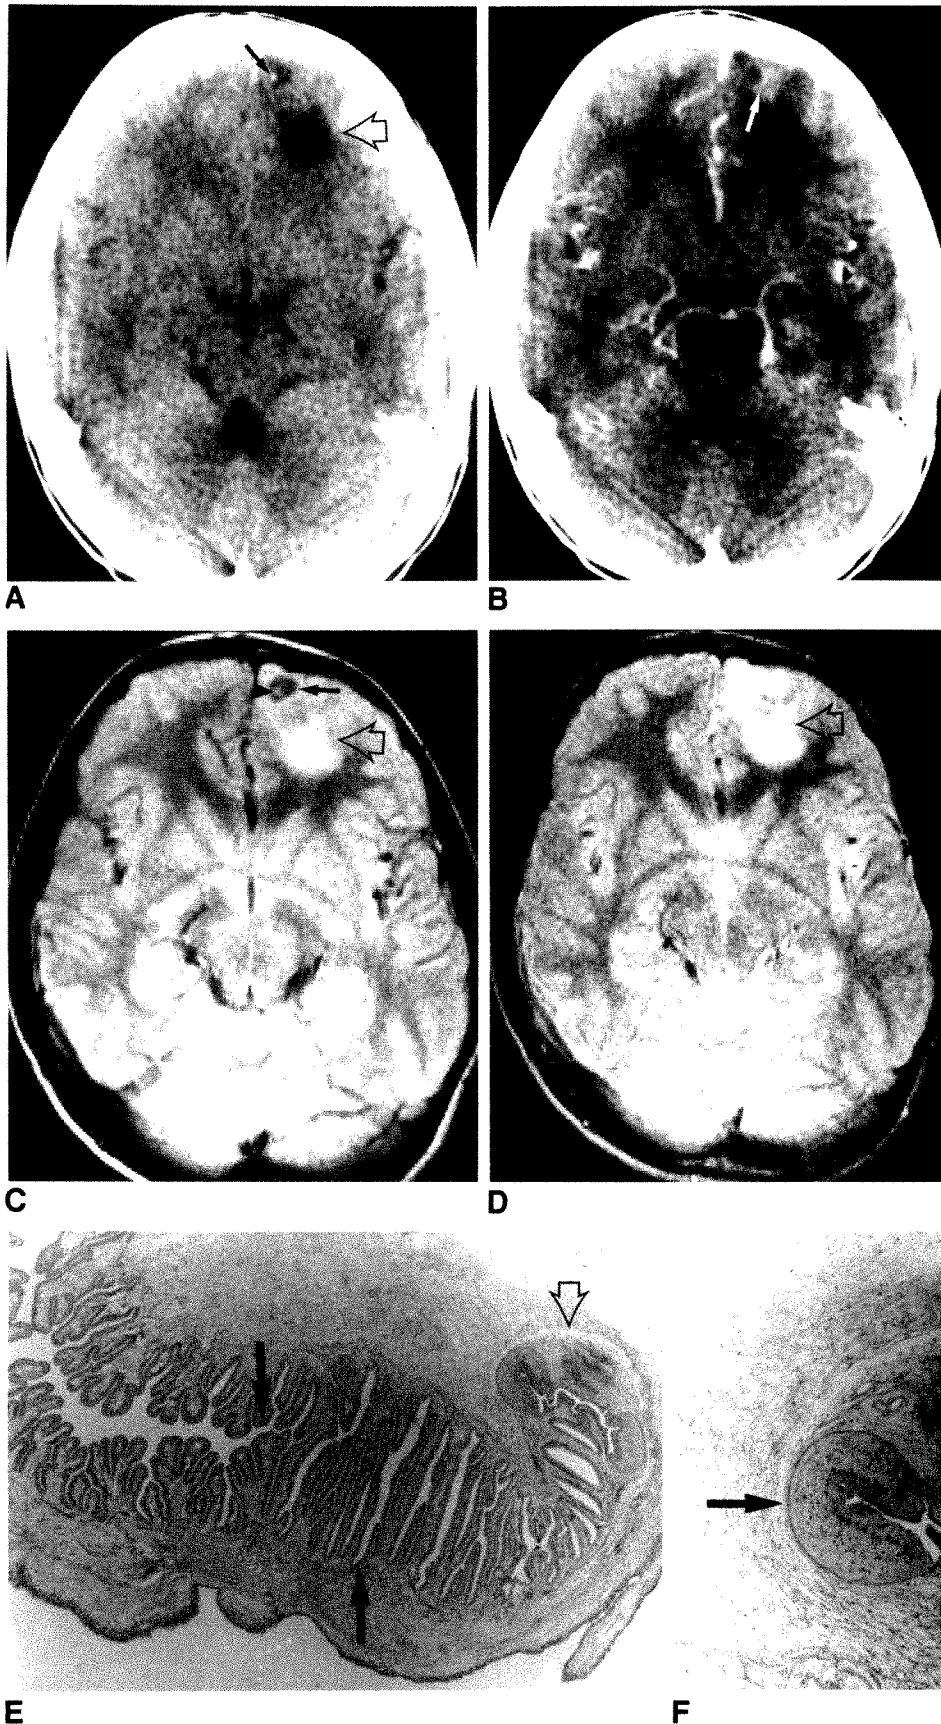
A, Nonenhanced axial CT image shows left frontal cysticercosis lesion in patient with seizures. Central calcification (solid arrow) is present within cyst, and there is a small adjacent area of decreased attenuation consistent with parenchymal edema (open arrow).
